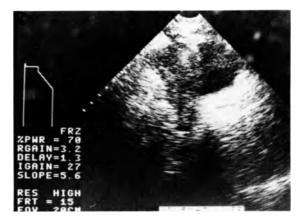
Transverse scan of pelvis with empty bladder. Note that no pelvic structures can be clearly identified. This underscores the importance of a full bladder for adequate pelvic sonographic examinations.
